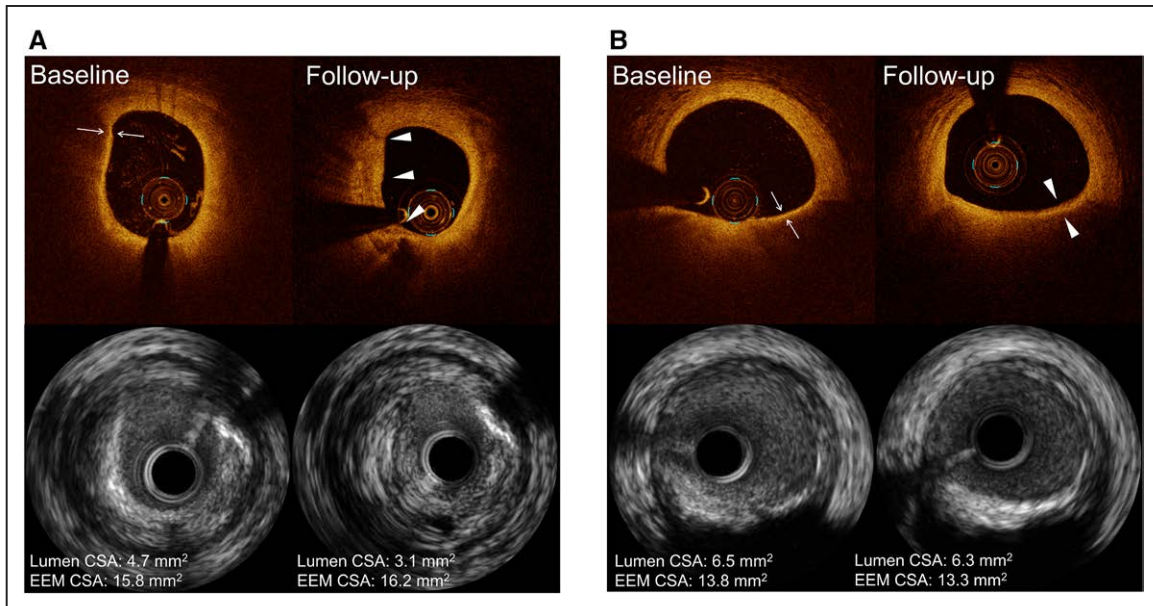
Representative cases of lesion phenotype change from thin-cap fibroatheroma to thick-cap lipidic plaque. A, Optical coherence tomography (OCT) shows a thin-cap fibroatheroma (arrows) at baseline. At 8-month follow-up, there was a layered pattern with a thick fibrous cap layer (arrow heads) and corresponding intravascular ultrasound cross-sections (bottom) show progression ($>0.5\text{-mm}^2$ decrease in lumen area). B, OCT shows a thin-cap fibroatheroma (arrows) at baseline. At 8-month follow-up, the fibrous cap increased in thickness (arrow heads) and corresponding intravascular ultrasound cross-sections (bottom) show no progression. CSA indicates cross-sectional area; and EEM, external elastic membrane.
